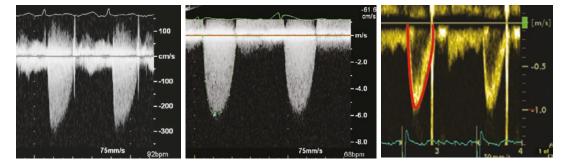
CW Doppler showing an example of moderate aortic stenosis with a triangular shaped profile (left) as compared to a patient with critical stenosis with a gradual
